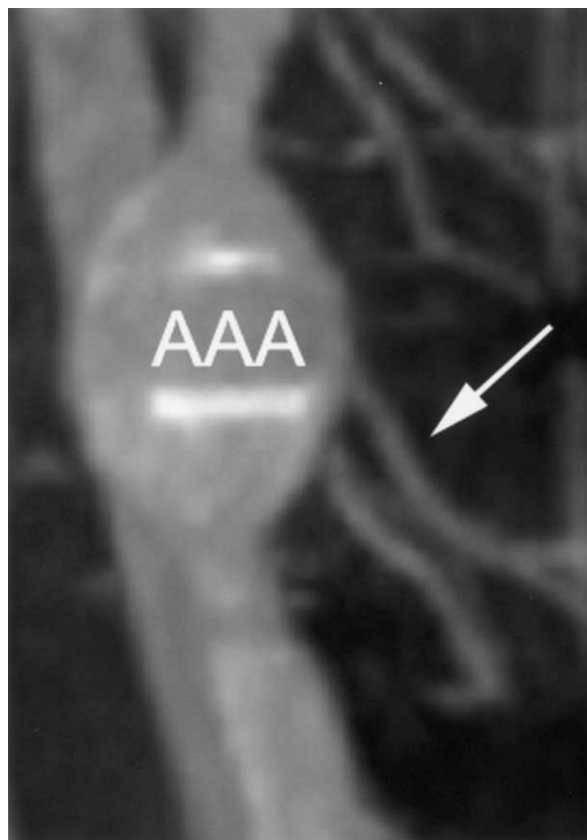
Three-dimensional reconstruction magnetic resonance image with gadolinium enhancement. Paired lumbar arteries (*ar-rorw*) are reimplanted onto the aneurysm sac (*AAA*). The inferior vena cava is also visualized.
